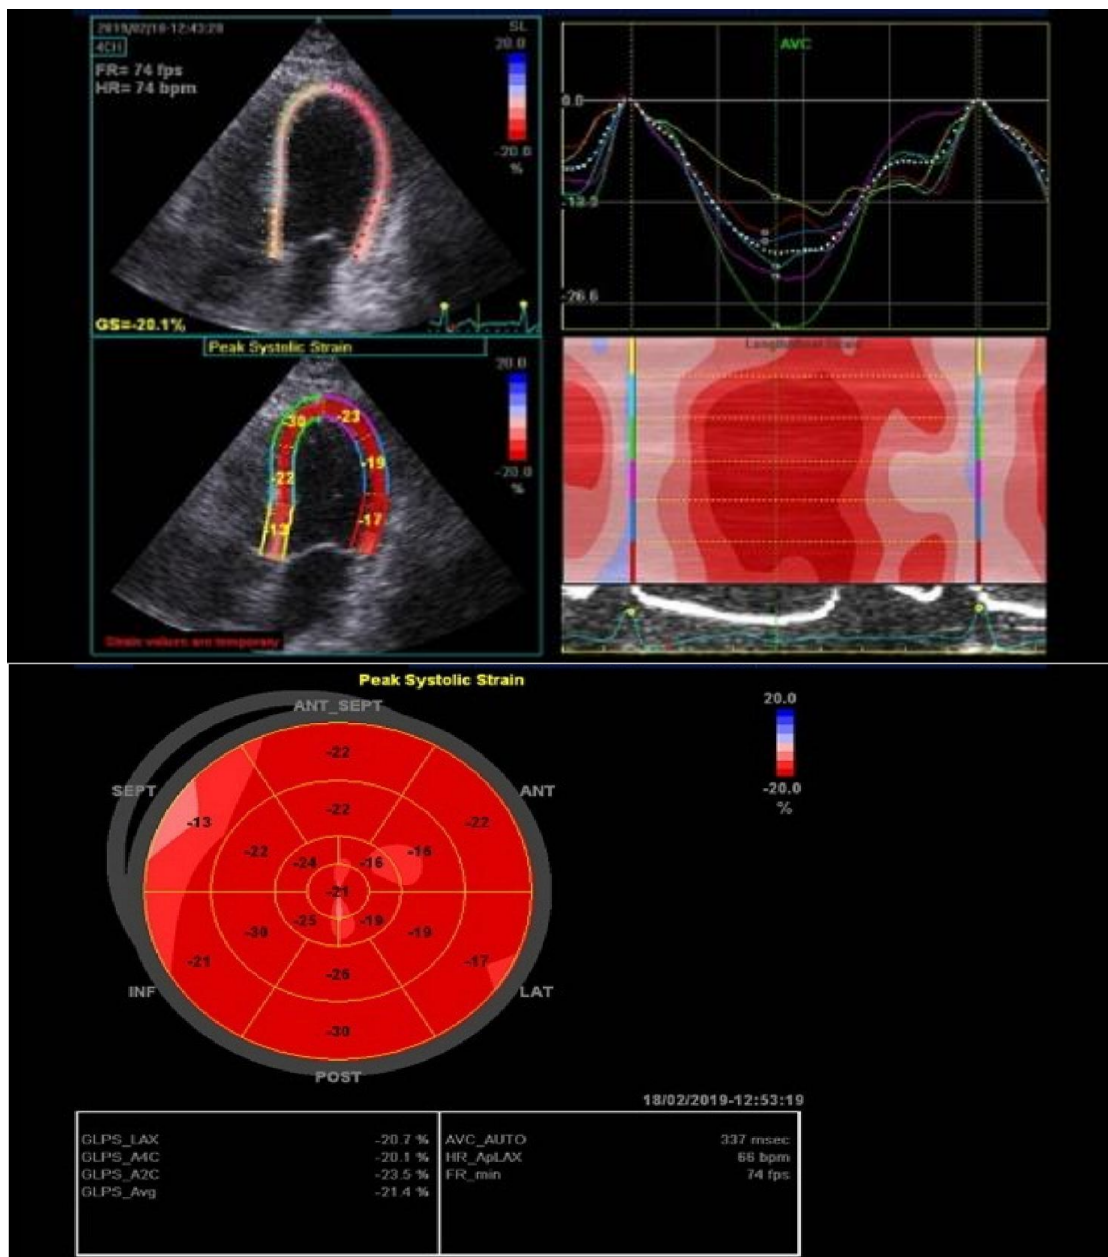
(A) longitudinal strain from apical 4C (-20.1%) (B) Bull eye map of CAE patient with GLS (-21.4%)
